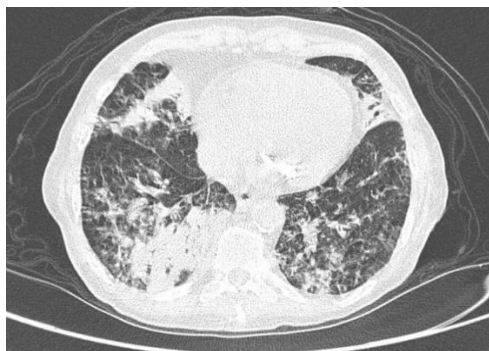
a - CT Thorax ON 11/12/2022
